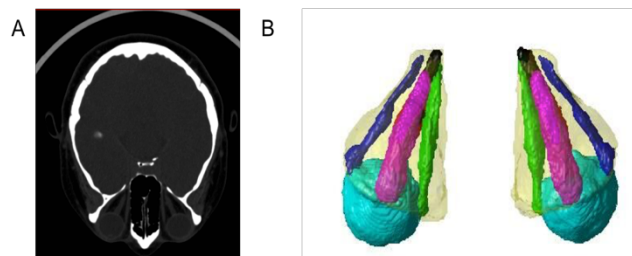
A. CT imaging of the head showing full view of the eye orbit. B. Result of segmentation showing: eye globes, optic nerve, orbital fat, superior rectus muscle, inferior rectus muscle, lateral
